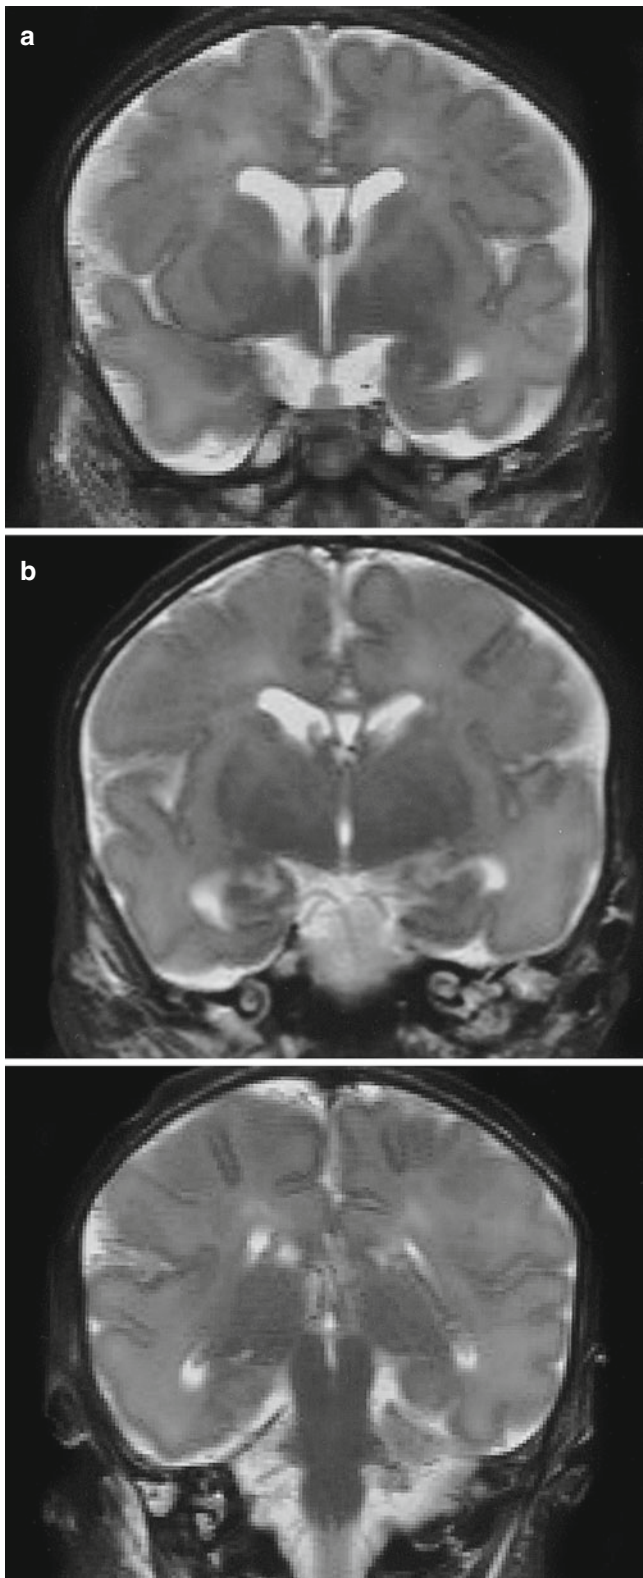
Fetal T2-weighted MRI taken at the 35th week of development. The three frontal (or coronal) sections show increasing development of the insulae and lateral fissures, and an increasing number of gyri and sulci. The basal ganglia (in a), the amygdala (in a) and the hippocampal region (in b) are easily recognized. Note the large cavum septi pellucidi and the prominent fornices (in a and b). The corpus callosum is visible in (a) and (b)
